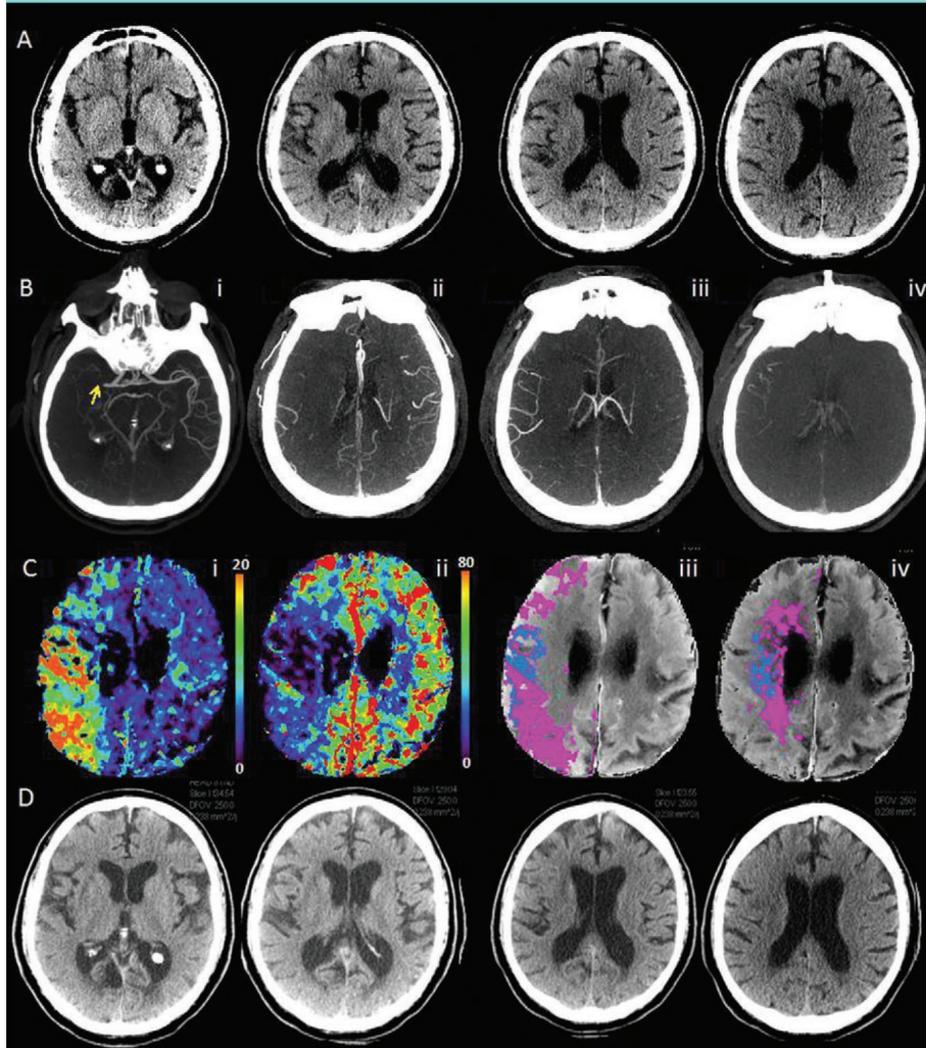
Multimodal CT images obtained 1 hour 32 minutes after symptom onset in a 67-year-old man with NIHSS of 17 and right hemisphere symptoms. *A*, Unenhanced CT ASPECTS score is 7. *B*, A proximal right M1 MCA occlusion extending to M2 MCA is seen (*i*). Multiphase CT angiography (three phases) maximum intensity projection images (*ii*, *iii*, and *iv*) are indicative of, at worst, one phase delay but with large regions having minimal pial arterial filling when compared with the contralateral side. The multiphase CT angiography score is 3, which indicates no treatment should be performed. *C*, Perfusion CT Tmax and CBF maps (*i*, *ii*). A CBF-defined predicted infarct core is 19 mL (*iii*, *iv*). A mismatch ratio of 7.1 indicates treatment should be performed. Multiphase CT angiography and CT perfusion images are incongruent for treatment decision. Fast (<60 minutes) recanalization was achieved by using endovascular thrombectomy. *D*, Unenhanced CT 3 days after admission shows the final infarct as hypointense.
